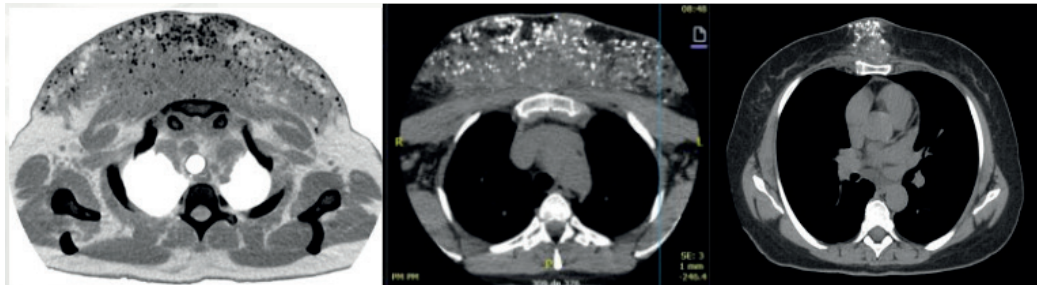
Chest CT scan: diffuse densification of the subcutaneous tissue of the anterior chest wall bilaterally with multiple hyperdense foci interspersed.
